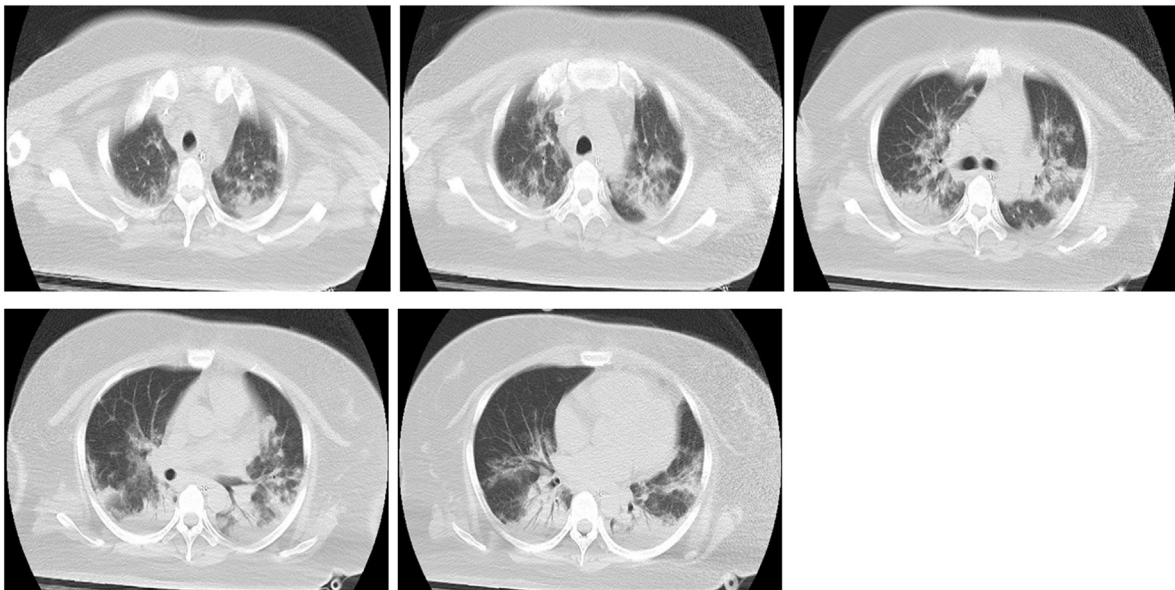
Chest CT on February 17.
